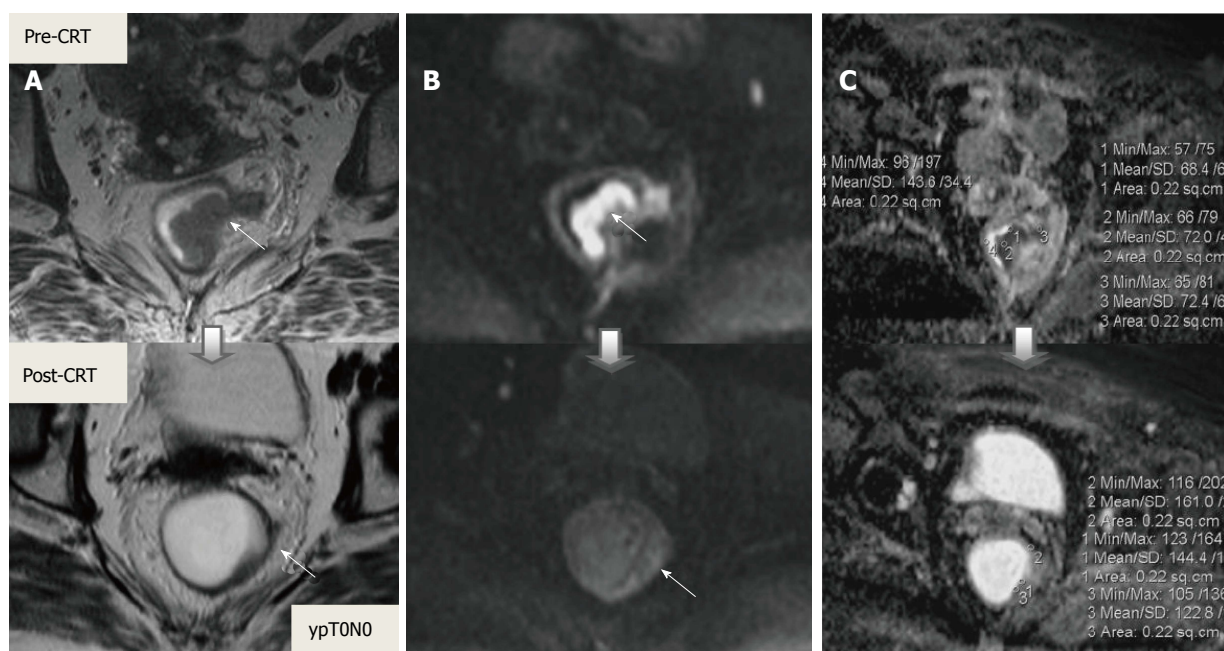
Post-chemoradiotherapy restaging using diffusion-weighted imaging in ypT0 rectal tumor. On T2-weighted (A), DW (B) and ADC (C) images in the same patient, baseline and post-CRT images are shown on upper and lower series, respectively. A: Posttreatment T2-weighted axial image shows a thick wall of low-signal-intensity fibrosis in the previous rectal tumor area (arrow). It is difficult to determine whether this area contains tumor cells or completely devoid of tumor cells (complete response); B: On posttreatment DW image (B-800), there is no diffusion signal in previous tumor area (arrows), compatible with complete response. In this case, DWI allows the correct differentiation of viable tumor from fibrosis; C: ADC images show post-therapy mean ADC increase ($0.70 \times 10^{-3} \text{ mm}^2/\text{s}$ vs $1.40 \times 10^{-3} \text{ mm}^2/\text{s}$) compatible with therapy response, but does not allow prediction of complete response. DWI: Diffusion-weighted imaging; CRT: Chemoradiotherapy.
